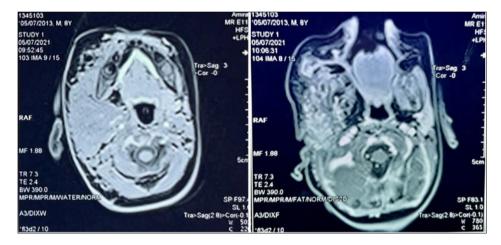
Axial T1 MRI before and after gadolinium injection showing the extension of the plexiform neurofibroma
